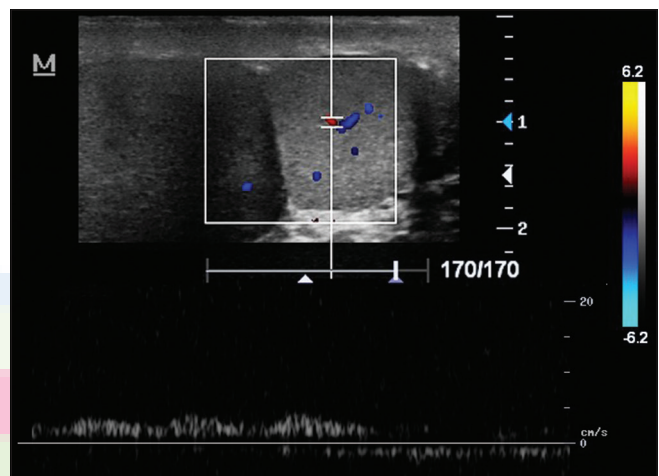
Color Doppler ultrasound shows a normal vascularity in the mass similar to the normal adjacent testis
